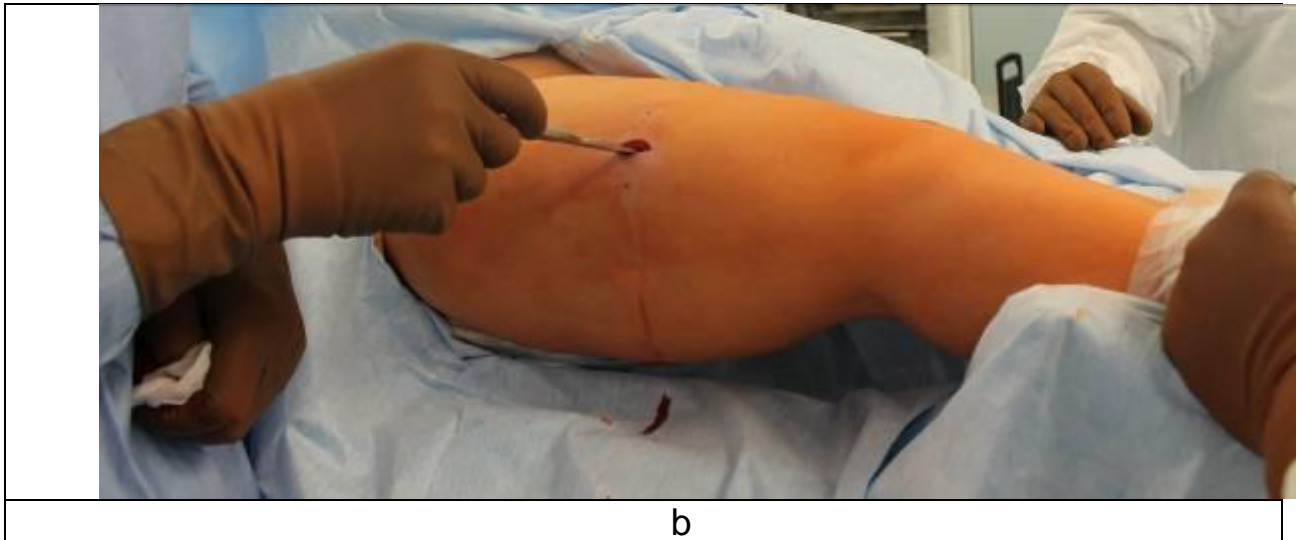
Insertion of SUV-clamp: forming a channel in the soft tissues to the bone and periosteal dissection
